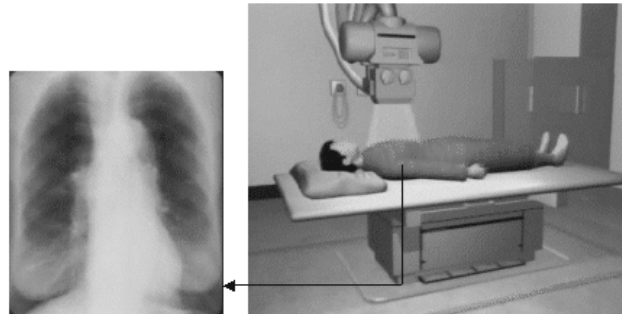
An x-ray film. The attenuation information for the patient's chest is superimposed onto the (horizontal) image plane. The output image shows overlying ribs, soft tissue and lungs. (Image courtesy of Curriculum Development Institute of Hong Kong)
